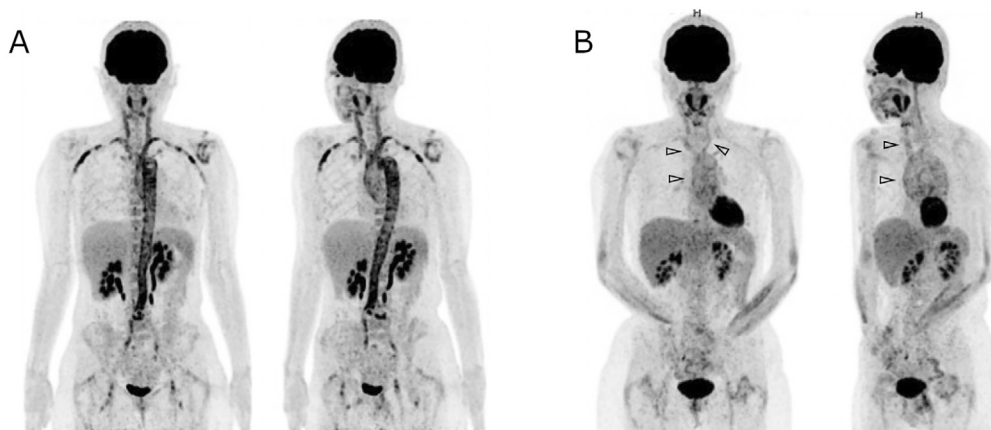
(A) Baseline positron emission tomography-computed tomography: a diffuse, intense fluorodeoxyglucose uptake is observed in the thoracic and abdominal aorta and common carotid, subclavian, iliac, and femoral arteries. (B) The 30-month follow-up findings of positron emission tomography-computed tomography showing a mild fluorodeoxyglucose uptake in the aorta, common carotid arteries, and subclavian arteries (arrowheads).
